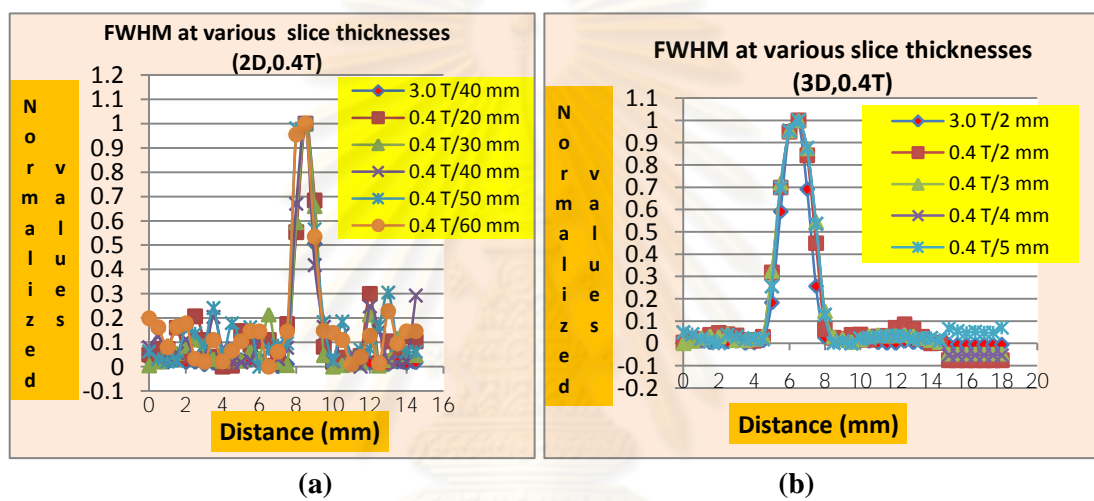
The FWHM versus slice thickness of (a) 2D and (b) 3D images at MRI 0.4 T compared to 40 mm at 2D and 2.0 mm at 3D slice thickness of 3.0 T MRI system
